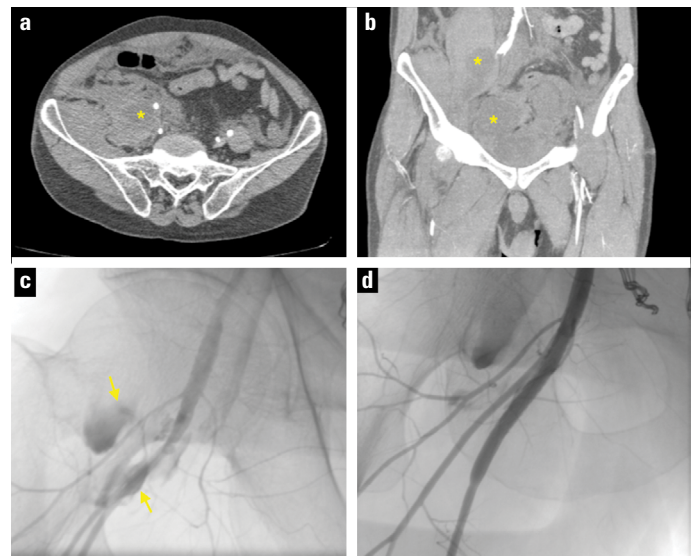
(a, b) Retroperitoneal hematoma observed on axial and coronal abdomen computed tomography images (c) Extravasation of contrast medium from the femoral artery on the angiographic image (d) Disappearance of the extravasation after graft-stent placement inside the femoral artery
